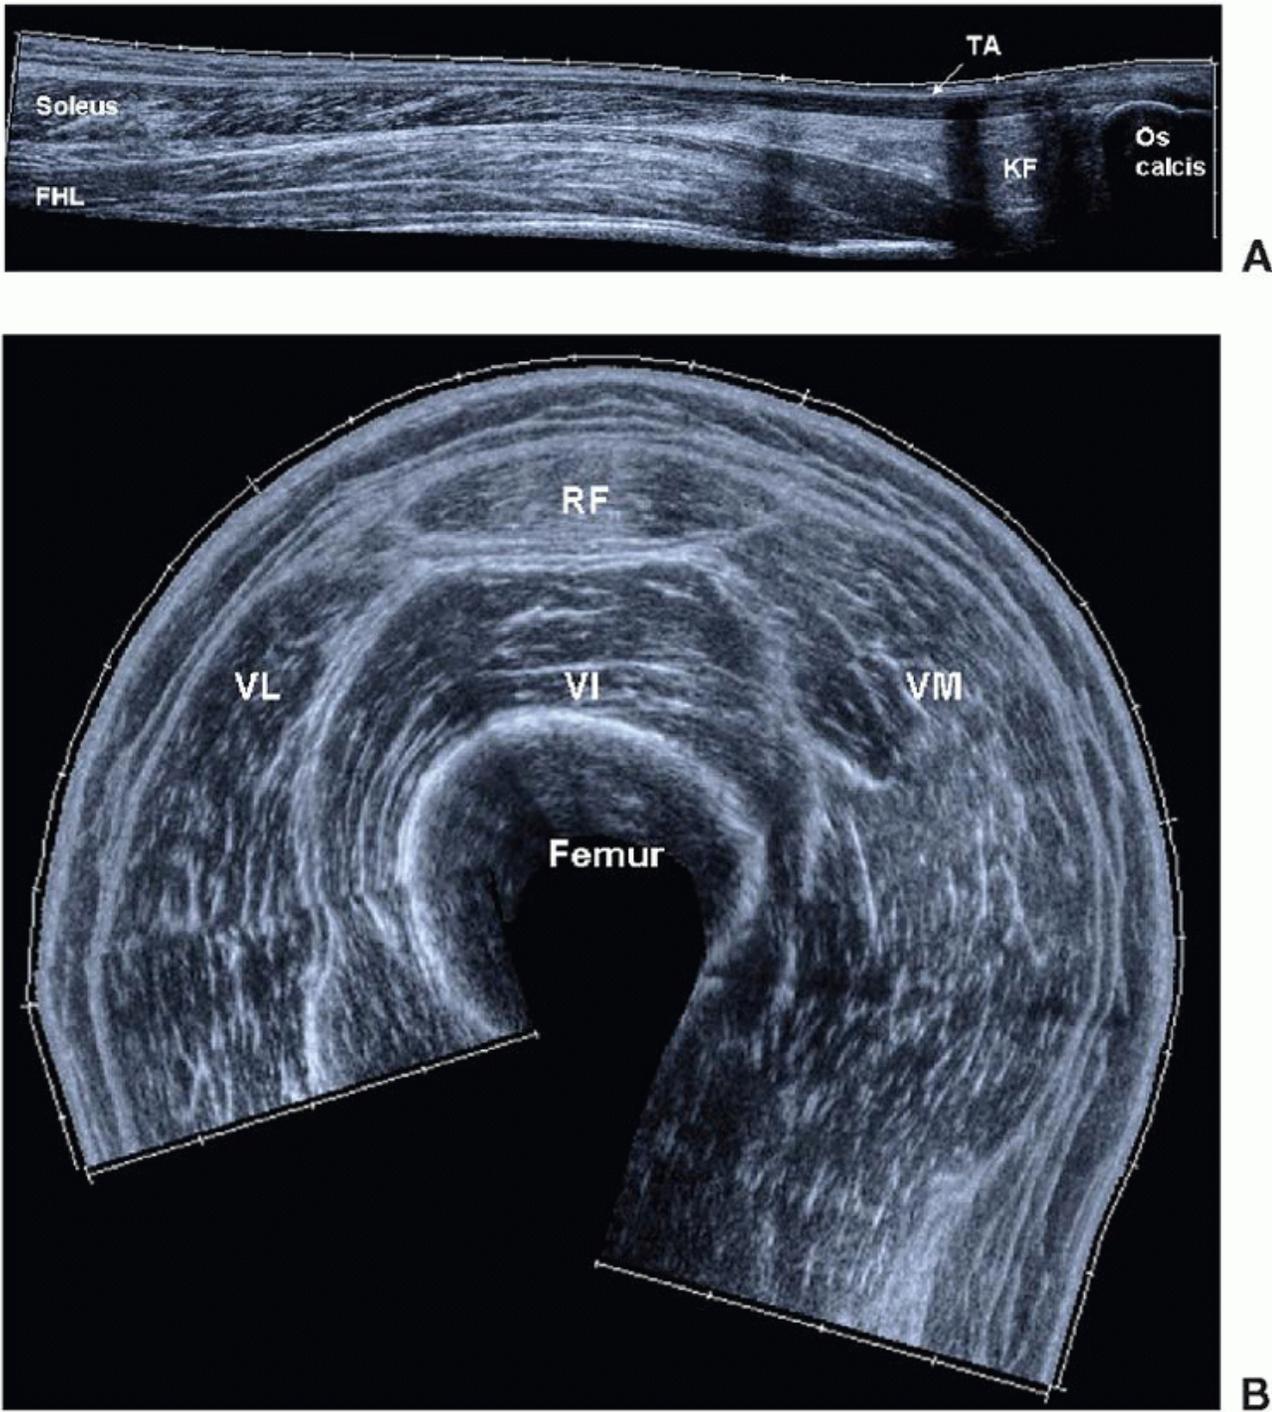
A: Longitudinal ultrasound scan of the lower calf showing the soleus and FHL muscles. The muscle boundaries are demarcated by echogenic fascia. Echogenic fibroadipose septa lie between hypoechoic muscle bundles and are oblique to the long axes of the muscles. FHL, flexor hallucis longus; KF, Kager's fat; TA, tendo Achilles. B: EFOV transverse scan of mid-thigh. Echogenic fascia outlines the muscle boundaries (of RF and VI, VM, and VL muscles). The fibroadipose septa are seen in cross section as echogenic dots and dashes. RF, rectus femoris; VL, vastus lateralis; VI, vastus intermedius; VM, vastus medialis. Muscles are anisotropic structures, and the appearance of a muscle will change with the angle of insonation. An individual muscle tends to be uniformly echogenic, but different muscles vary in echogenicity. Muscle echogenicity can be altered by pathology (e.g., fatty infiltration and infection cause increased echogenicity).
